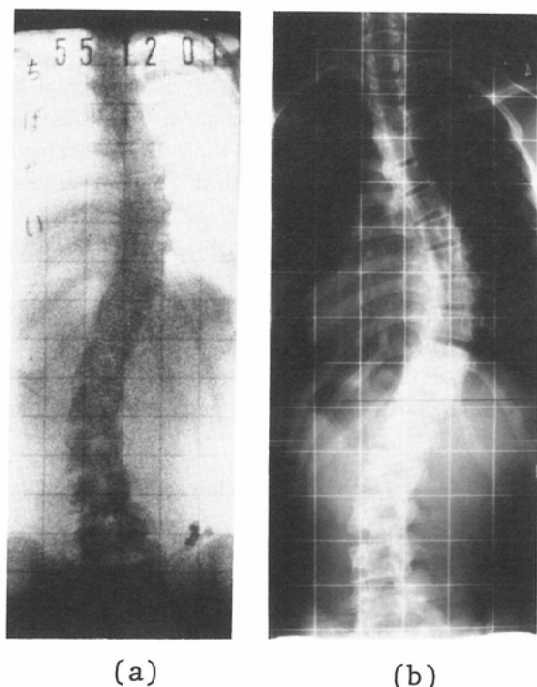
Comparison of spinal X-ray photography between low dose X-ray photography system and usual X-ray system (same examinee). (a) Spinal X-ray photography by low dose system, (b) Spinal X-ray photography by usual X-ray system.
